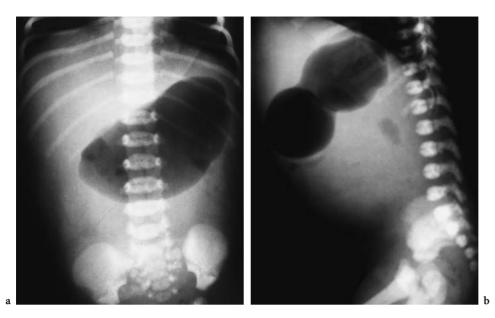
Midgut volvulus. Supine (a) and lateral (b) radiographs show distension of the stomach and duodenum with some distal intestinal air in a 12-day-old infant with severe vomiting
